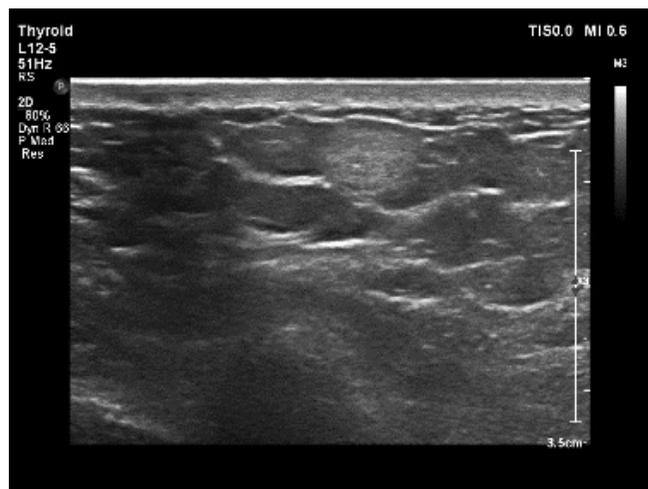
Ultrasound image shows a medial retroareolar, hyperechoic solid mass with well circumscribed
